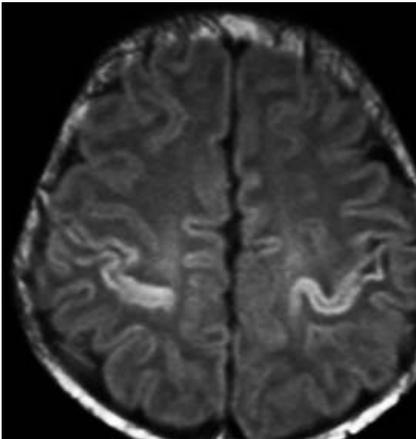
Term-born infant of a mother with solutio placentae. T1-weighted image of an infant with hypoxic-ischaemic encephalopathy at day 10 of life. The image shows higher signal-intensity in the peri-Rolandic cortex than in the corona radiata.
